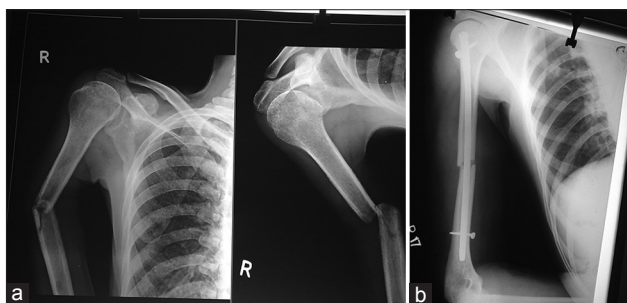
(a) Preoperative radiograph of fracture shaft of humerus of 40-year-old man; (b) Postoperative radiograph showing fracture fixation with interlocking nail.
